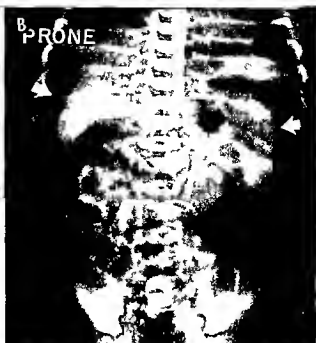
Pneumoperitoneum. A, radiograph with the patient supine visualizes a vague oval lucency over the upper abdomen with the fetal form ligament outlined by air. This could be due to perforation in many places but in this infant was secondary to the mother's perforation of the rectosigmoid. Free air can be
